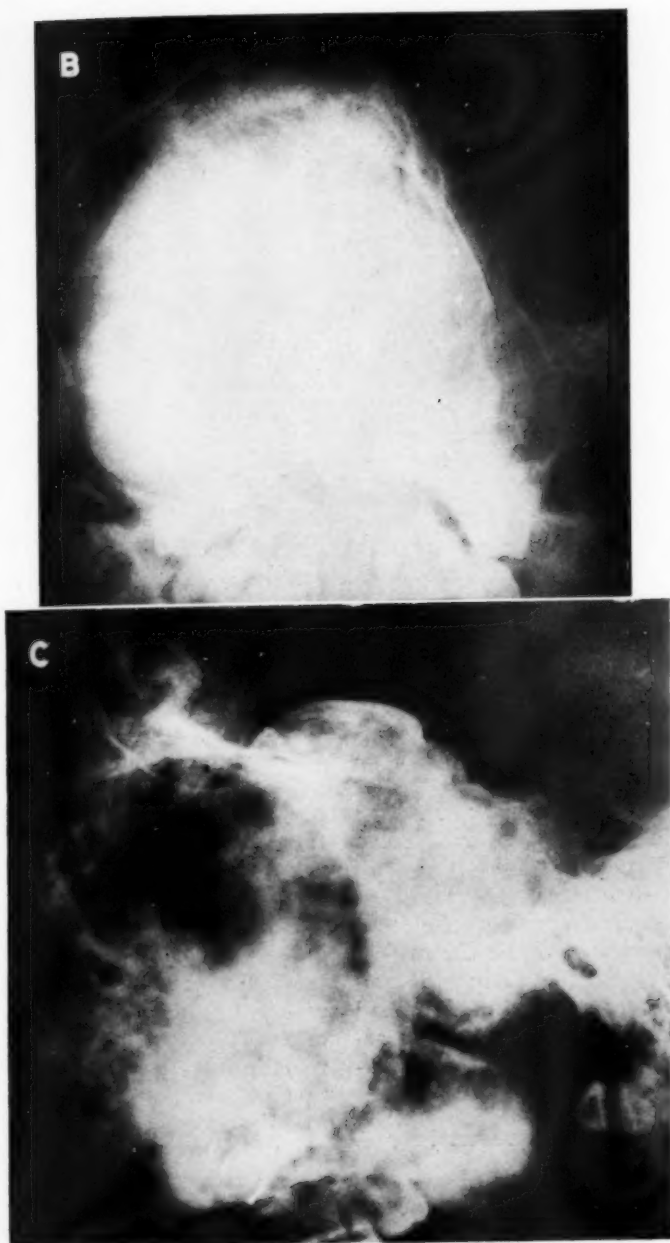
B and C. Case 7. B. Appearance four years after Fig. 7. A. C. Extent and character of tumor as seen in lateral view thirteen years after initial roentgen study.
